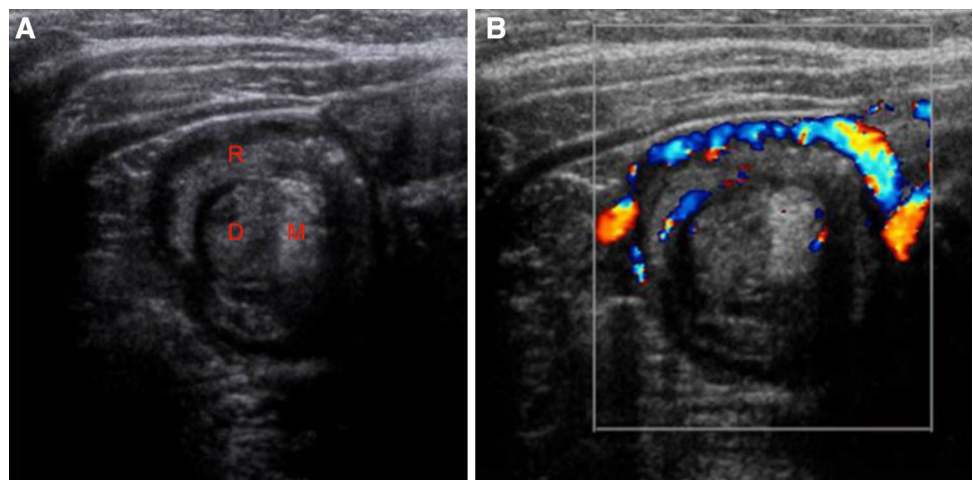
Intestinal intussusception. a Sagittal US image demonstrates the target sign: the intussusciens (receiving loop *R*) contains the infolded intussusceptum (donor loop *D*), the attached mesentery (*M*) is dragged between the two limbs. b Color Doppler image shows the double ring sign
